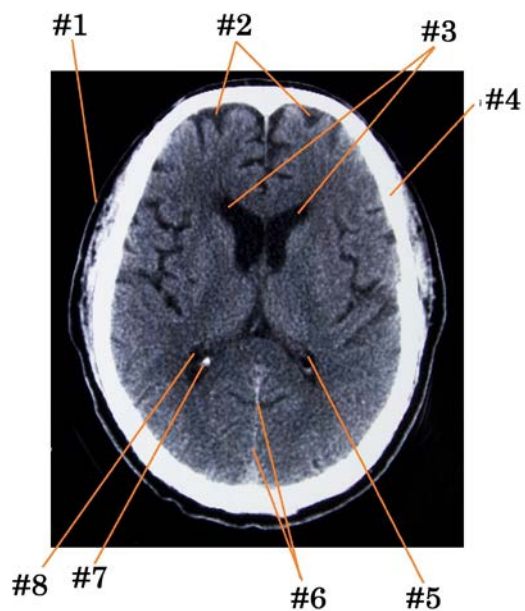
CT axial cross-sectional image of the middle brain.
